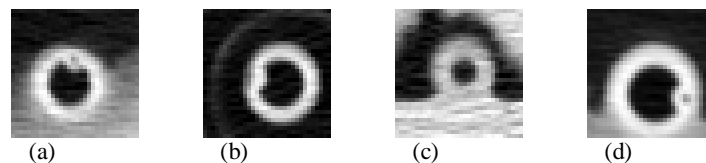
(a)-(d) Images of rectal tubes acquired during the CT scan are detected and identified as false positives
